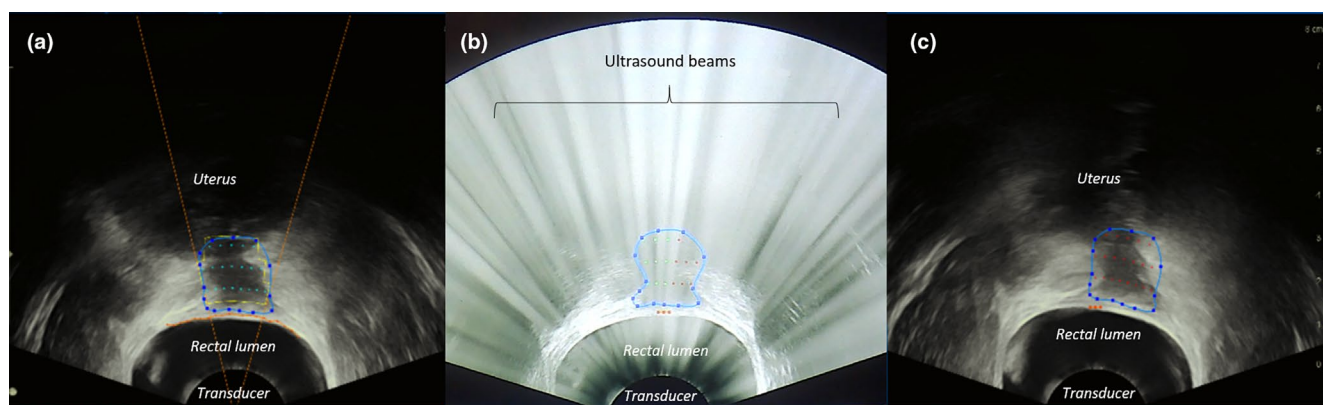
Planification of high-intensity focused ultrasound (HIFU) treatment and treatment. The entire volume of the nodule is divided in several slices every 1.7 mm. This figure represents one slice of treatment. (a) The rectal nodule is outlined by the physician (blue dotted line). The software determines the number of thermal lesions required to treat the entire slice (green dots) and the area of thermal diffusion (inside the yellow line). The distance between two vertical points is 5 mm. (b) Shows the ultrasound imaging during the HIFU treatment. The image is blurred by the HIFU shots. When the thermal lesion is formed, the green dot turns red. (c) The treatment of this slice is completed, all the green dots turn red. The probe move to the coming slice 1.7 mm above and so on until the entire nodule is treated.
